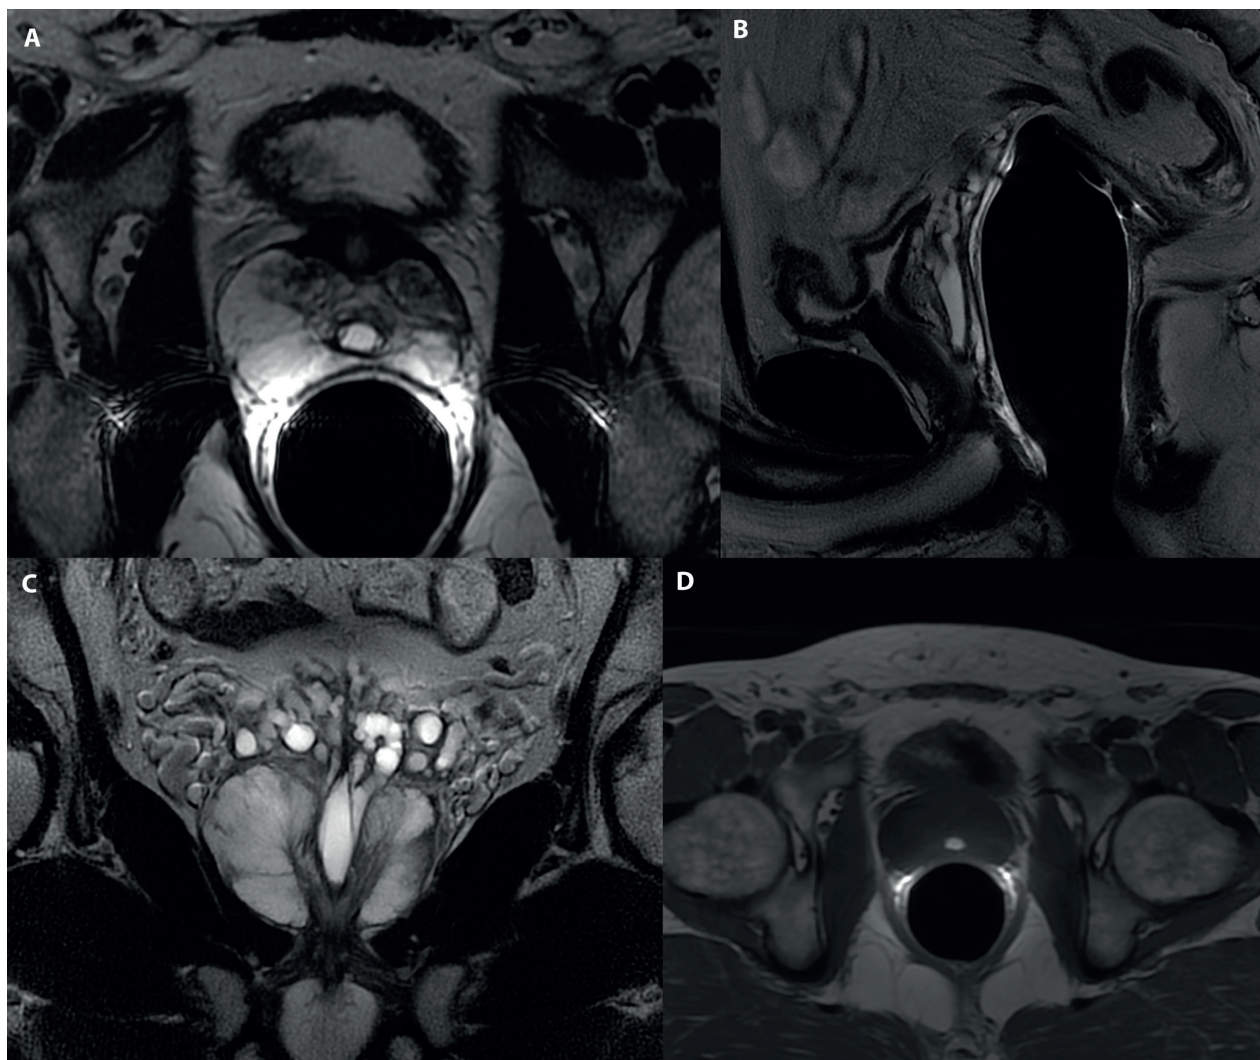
Prostatic utricle cyst in the same patient as in Figure 1. Axial (a), sagittal (b), and coronal (c) spin-echo T2-weighted MR images show a midline high-signal-intensity prostatic utricle cyst. Axial (d) spin-echo T1-weighted MR image shows high signal intensity of the cystic lesion due to recent episode of haematospermia.
